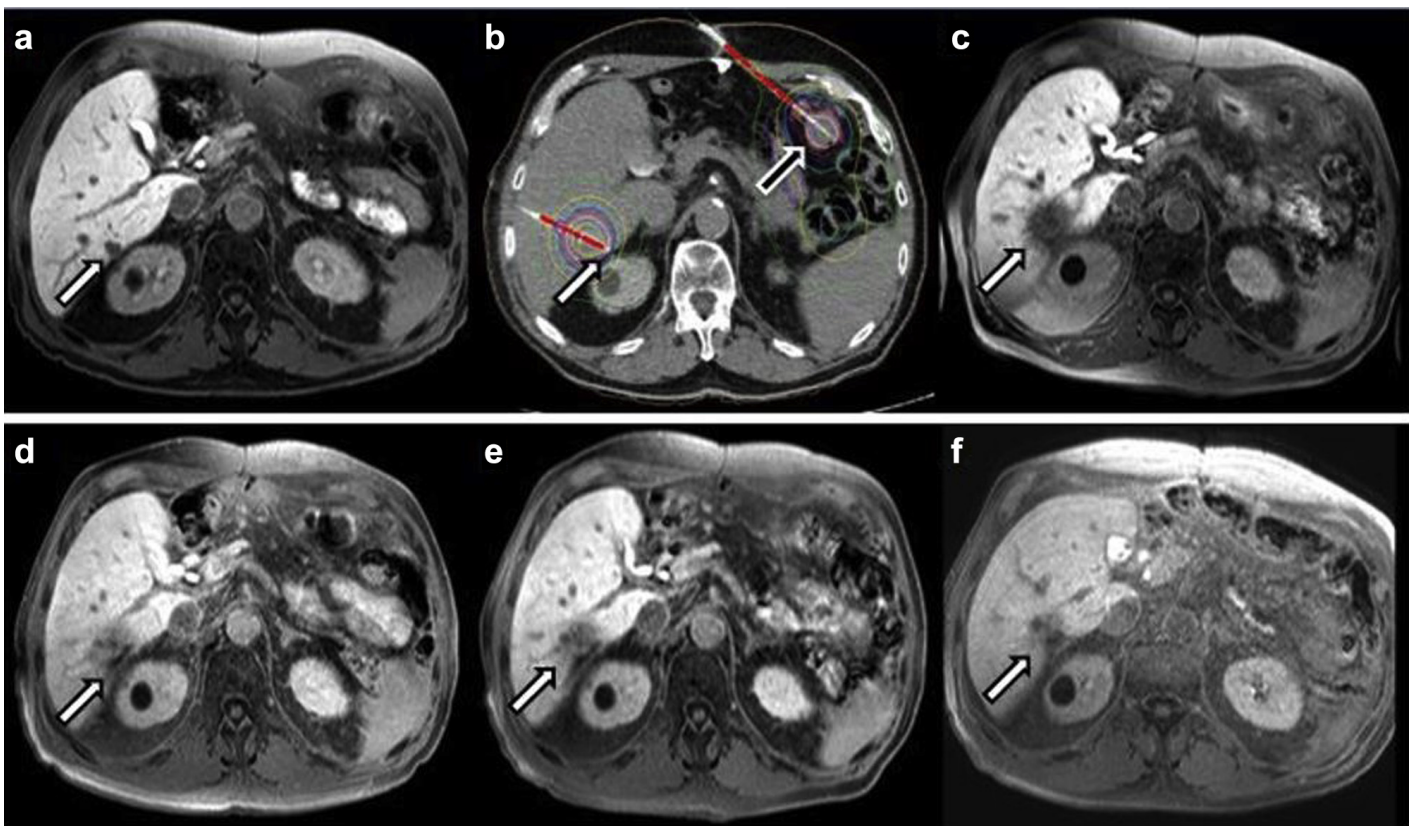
(a): Baseline Gd-EOB-DTPA enhanced T1w MRI. White arrow indicates gastrointestinal stroma tumor metastasis in liver segment 6. (b) Demonstrates inserted brachytherapy catheters in the liver lesion (white arrow) and in a second extrahepatic peritoneal lesion (black arrow). Lines represent isodoses with red line showing 12 Gy. (c–f): Followup and local control documentation of hepatic lesion 3 (c), 6 (d), 9 (e), and 30 (f) months after iBT. Note the Gd-EOB-DTPA enhancement defect (dark rim around lesion) after iBT in (c) and recovery in (d–f). (For interpretation of the references to color in this figure legend, the reader is referred to the Web version of this article.)
